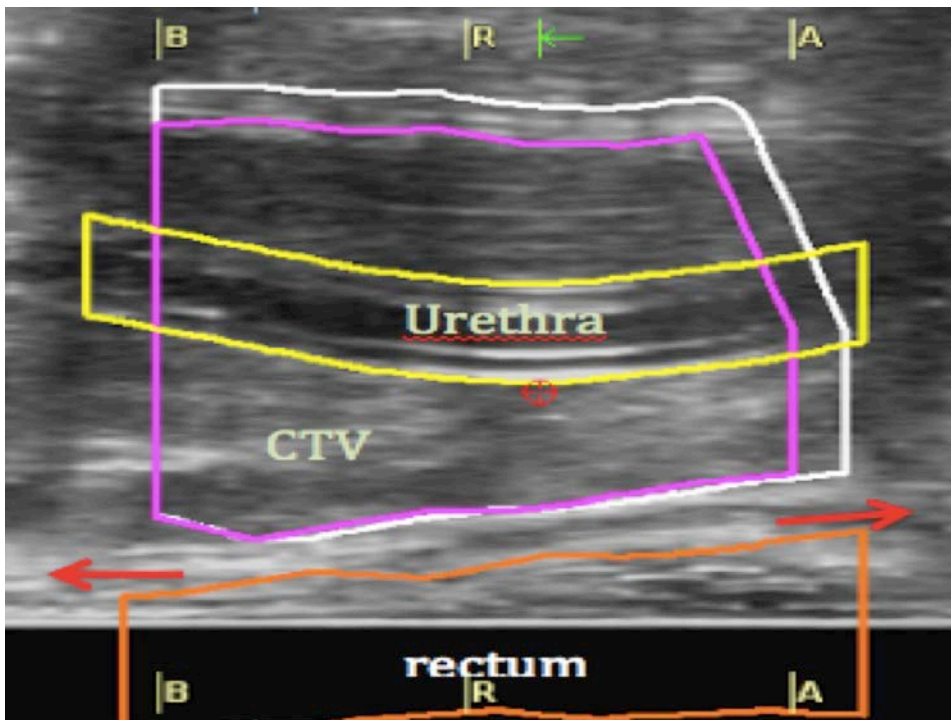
Sagittal ultrasound (US) image showing the prostate and different rectal contours. The rectal structure includes a 10 mm margin that is
